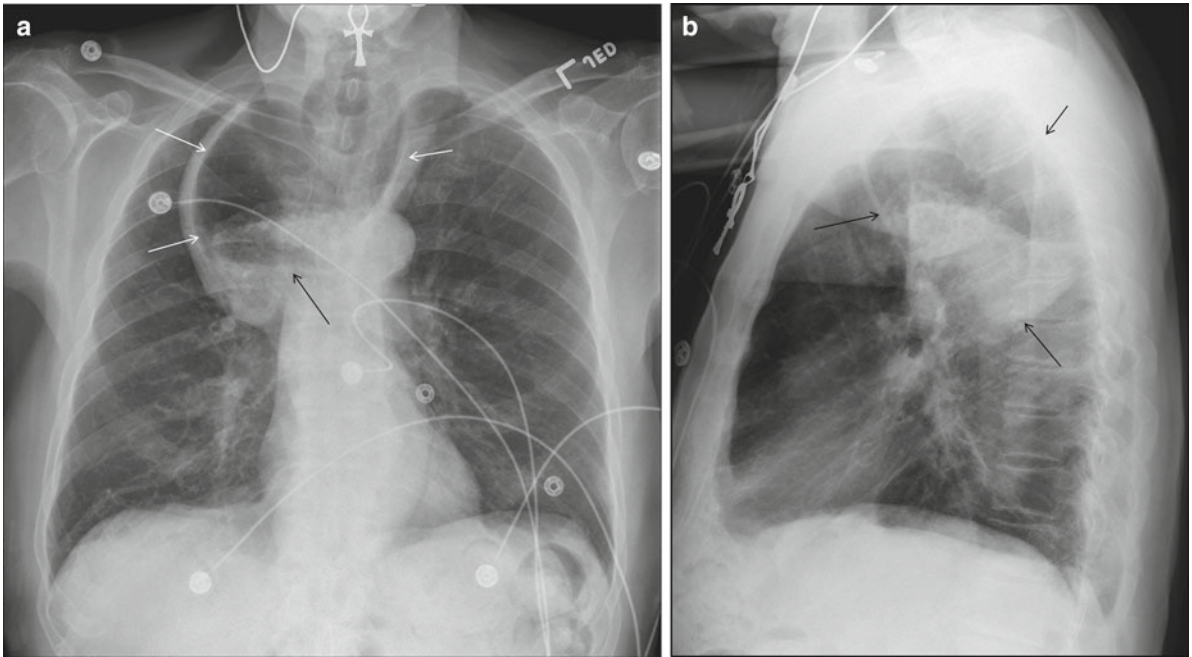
A 90-year-old man presents with halitosis and otherwise asymptomatic. (a) PA chest X-ray shows a large air-fluid (black arrow) containing structure (white arrows) in the upper chest. (b) Lateral chest
